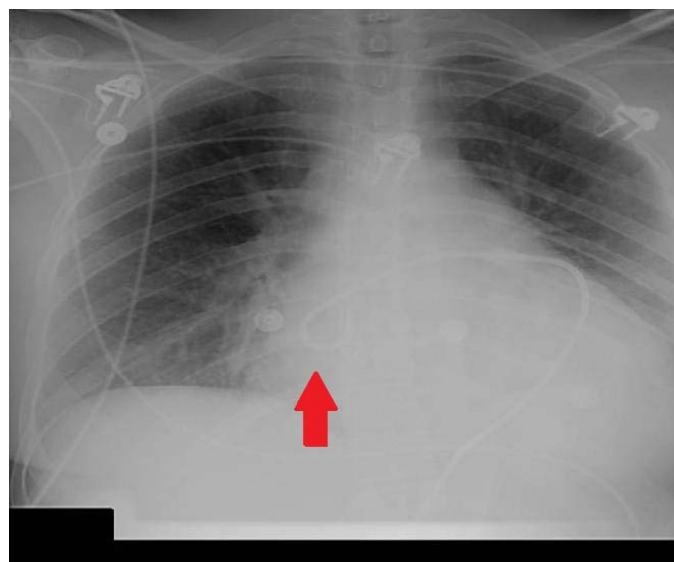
Portable X-ray of patient after placement of pericardial drain (arrow), with reduction in size of cardiac silhouette.
